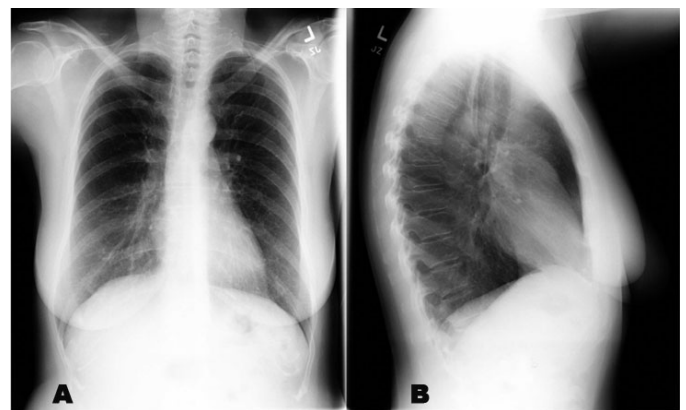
(A, B) 2 View chest X-ray (Photo Courtesy of Dr. Jay Crowther).
